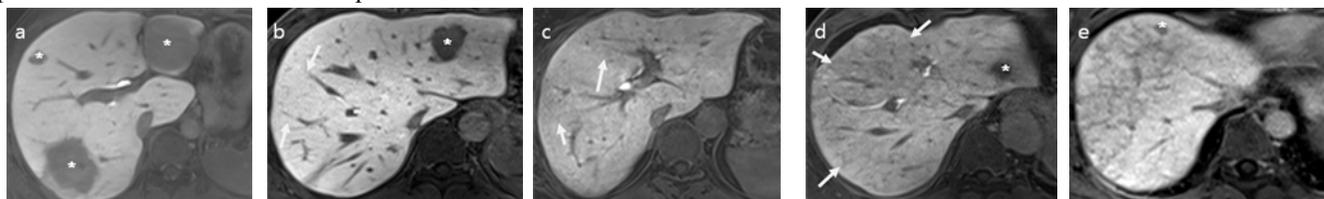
Various degrees of sinusoidal obstructive syndrome on hepatobiliary phase images of EOB-MRI. (a) The liver shows homogeneous high signal intensity (confidence level = 1). (b) Subtle hypointense reticulations (arrows) in only few sections, but not definite (confidence level = 2). (c) Fine hypointense reticulations in limited areas (arrows; confidence level = 3). (d) More prominent reticulations in all sections (arrows; confidence level = 4). (e) The liver parenchyma shows marked hypointense reticulations (confidence level = 5). Nodular lesions with hypointensity are metastatic lesions (asterisks).
